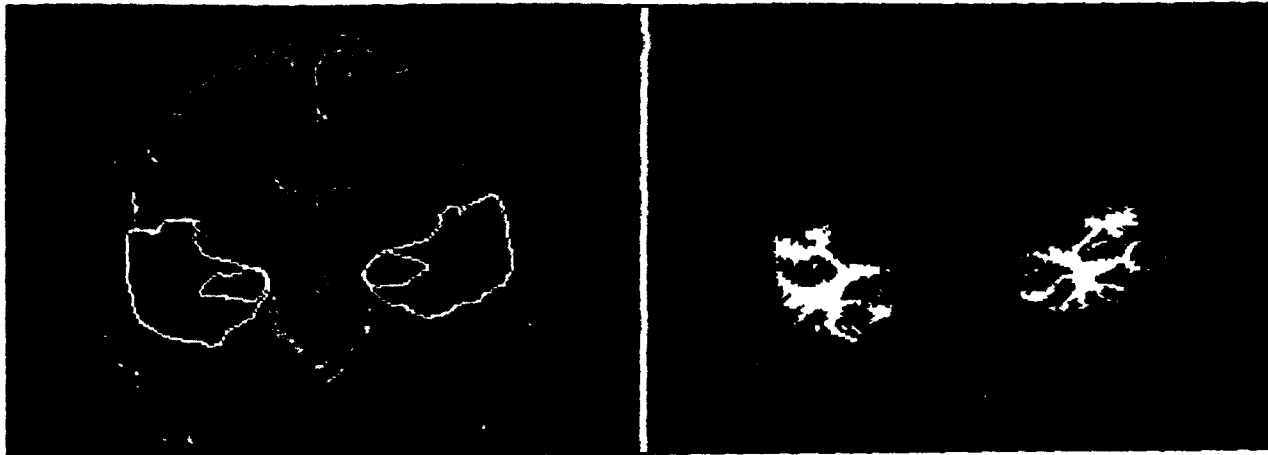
Coronal magnetic resonance image of a 42-year-old normal, healthy man. Left, Outline of regions of interest—temporal lobes and hippocampi. Right, Segmentation of the image into gray matter (dark gray), white matter (light gray), and cerebrospinal fluid (black).
